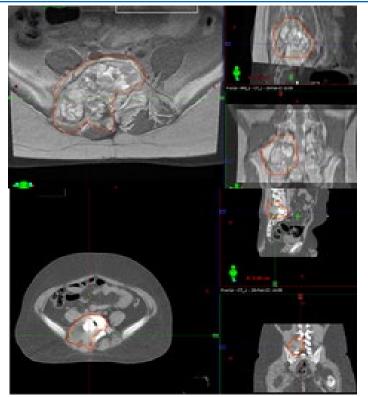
Contouring of the CTV after overlaying the MRI with the planning CT in IMRT planning.
